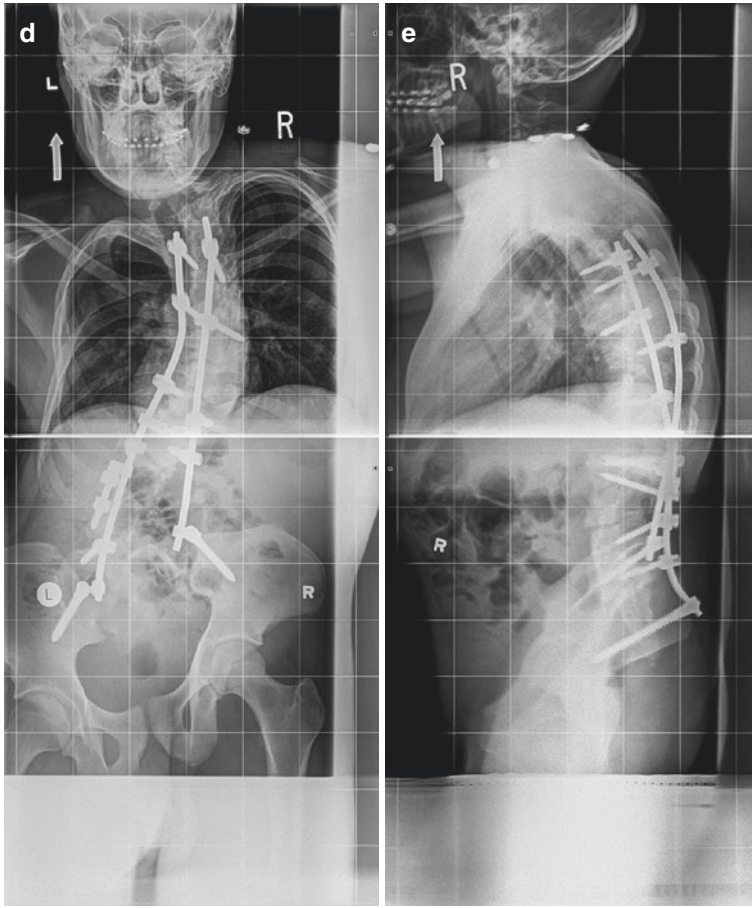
(continued) (d) The patient underwent a two-stage instrumented spinal fusion to correct his severe kyphoscoliosis. This AP whole spine radiographs shows
